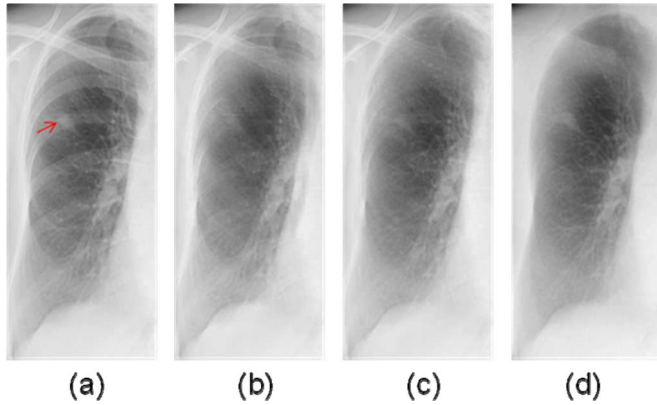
Results for abnormal chest radiographs with a nodule that is mostly overlap with a rib. (a) An original abnormal chest radiograph with a nodule (indicated by a red arrow), (b) a VDE soft-tissue image obtained by use of our original MTANN technique, (c) a VDE soft-tissue image obtained by use of our new MTANN technique, and (d) the corresponding “gold-standard” dual-energy soft-tissue image.
